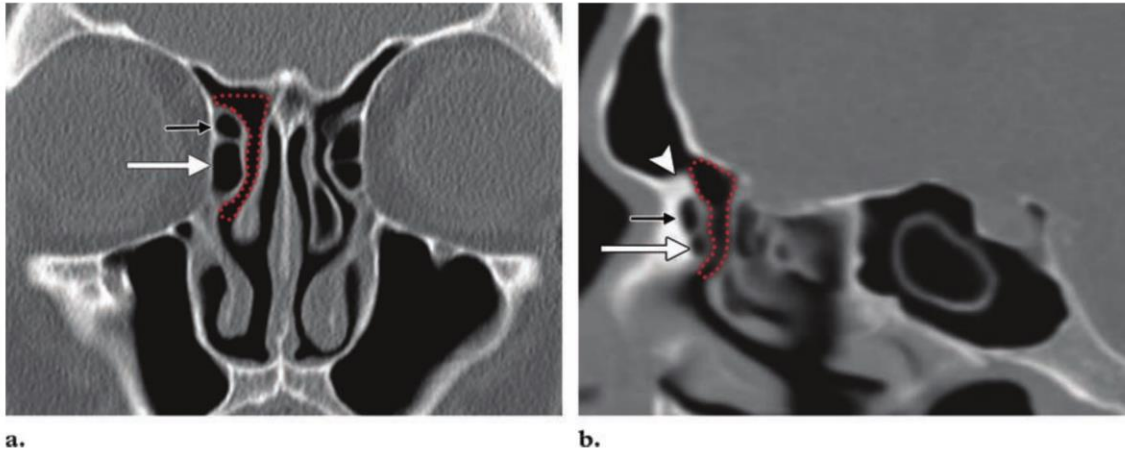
Normal frontal recess anatomy. Coronal (a) and sagittal (b) CT images show the right frontal recess (dotted red line), which is bounded anteriorly and laterally by an agger nasi cell (white arrow) and a type 1 frontal cell (black arrow), medially by the middle turbinate, and posteriorly by the ethmoid bulla and bulla lamella. The nasofrontal process (arrowhead in b) forms the floor of the frontal sinus and demarcates the level of the frontal sinus ostium.
